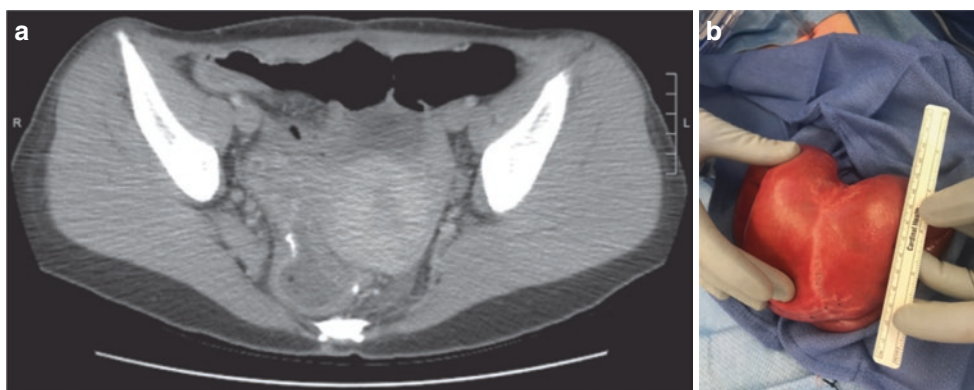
(a) Dilated side-to-side stapled anastomosis: CT image of a patient who underwent total proctocolectomy with J-pouch and had a side-to-side anastomosis at the ileostomy takedown site. She had symptoms of intermittent obstruction causing weight loss and chronic
